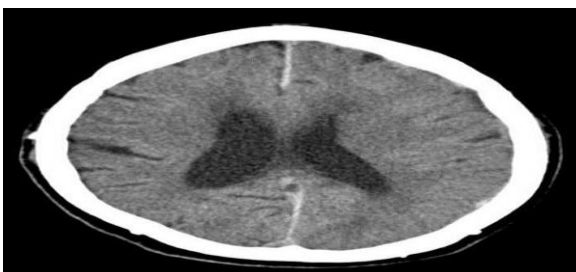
An axial CT of the brain shows an interhemispheric hemorrhage.
